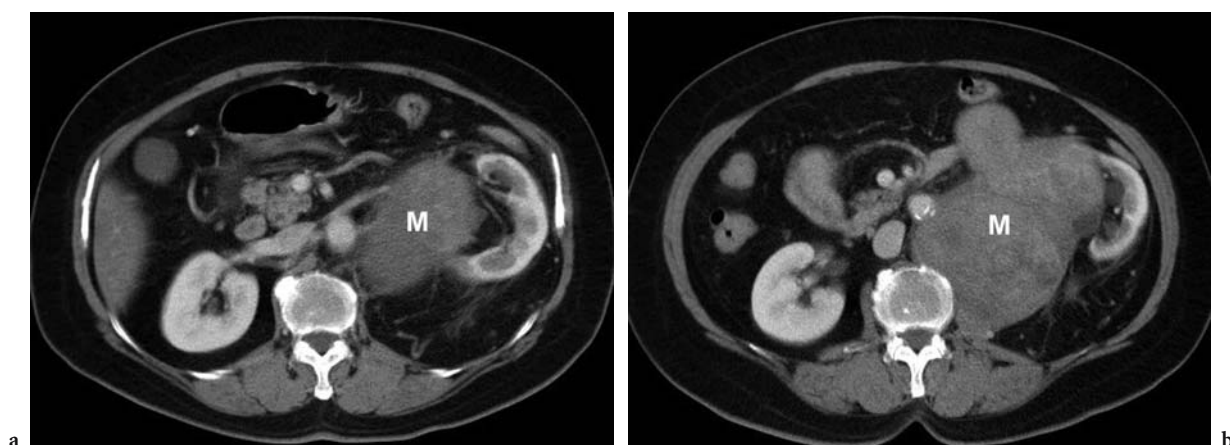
Retroperitoneal spindle cell tumor extending to the renal sinus in a 63-year-old woman. a, b Axial contrast-enhanced CT scans show a bulky lobulated soft-tissue-density mass (*M*) in the left para-aortic space and extending to the left renal sinus. It causes dilation of the left renal pelvis and calyces.
